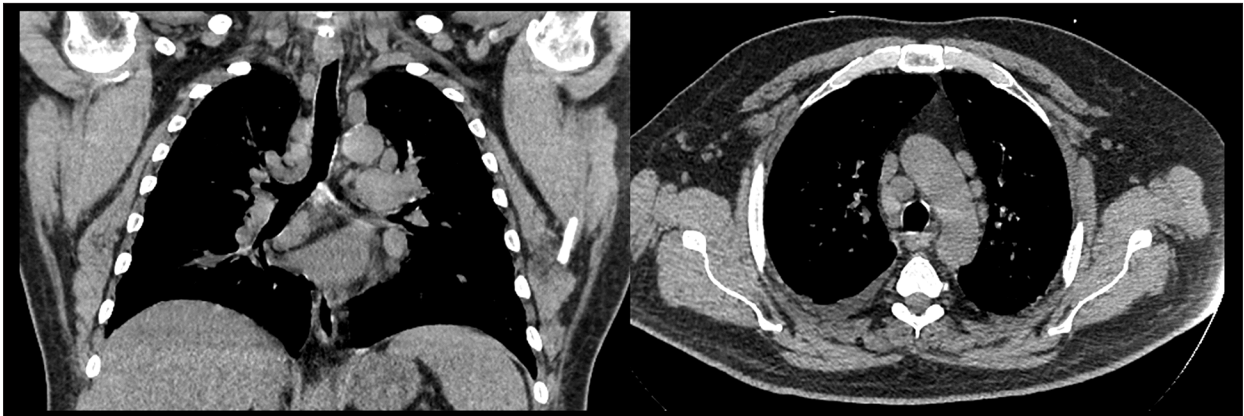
Computed tomography without contrast demonstrating diffuse mediastinal and hilar lymphadenopathy with conglomeration of lymph nodes in the subcarinal region.
